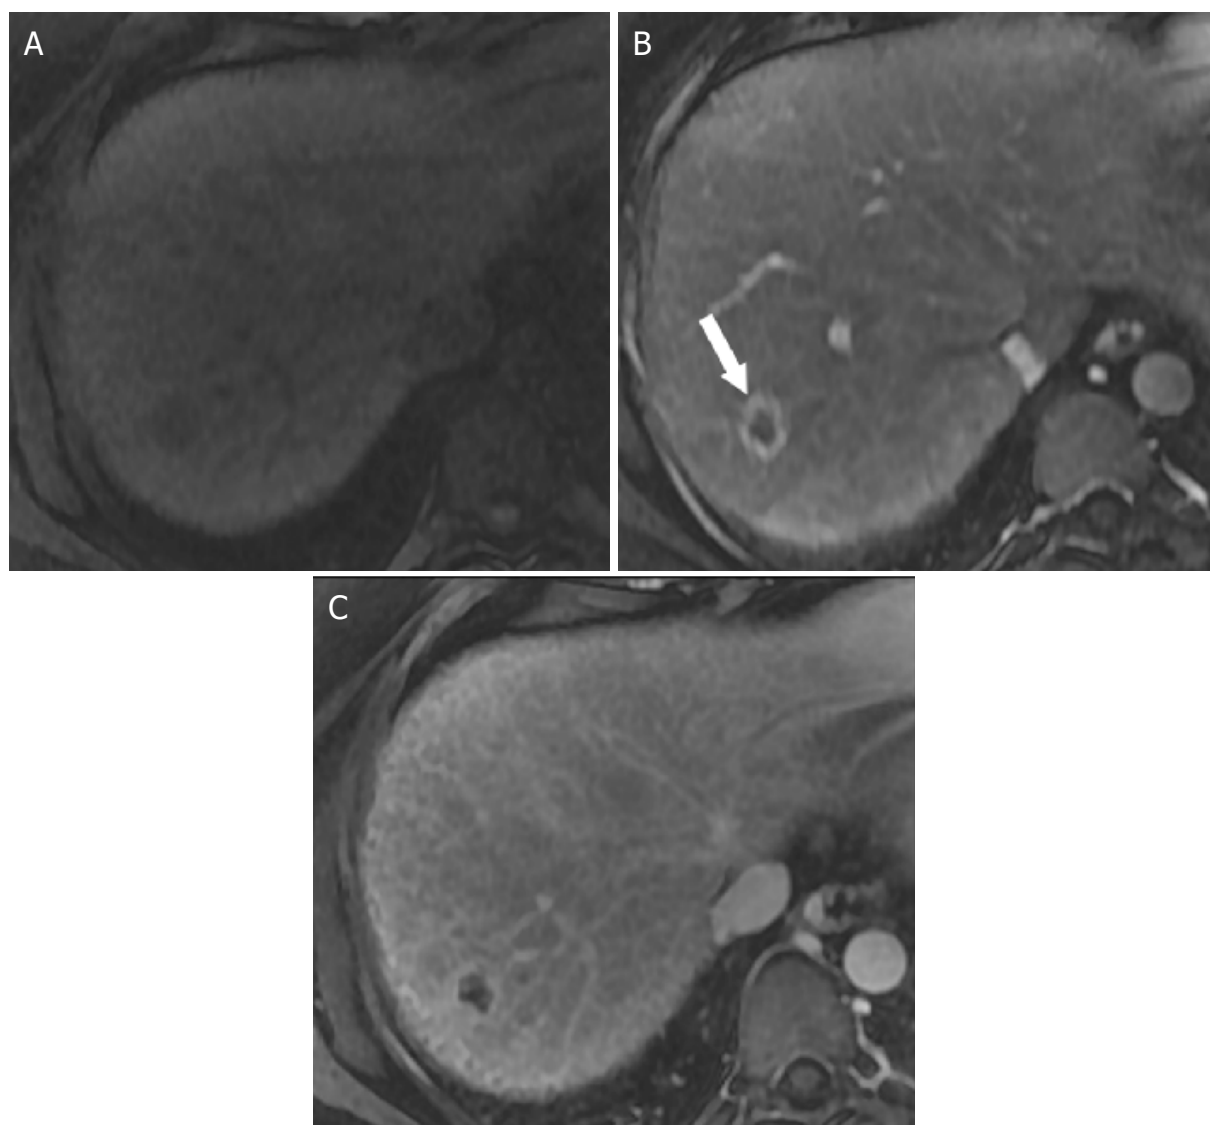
Peripheral Arterial Phase Hyperenhancement. Axial T1-weighted fat saturated MR images of the abdomen prior to (A), and during the arterial phase (B) and delayed phase (C) of dynamic post extracellular contrast images. The 26 mm observation in the right hepatic lobe demonstrates peripheral arterial phase hyperenhancement (white arrow). This feature does not qualify as the major feature of nonrim arterial phase hyperenhancement and should lead the radiologist to assign the category of LR-M (probably or definitely malignancy, but not HCC specific). HCC: hepatocellular carcinoma
